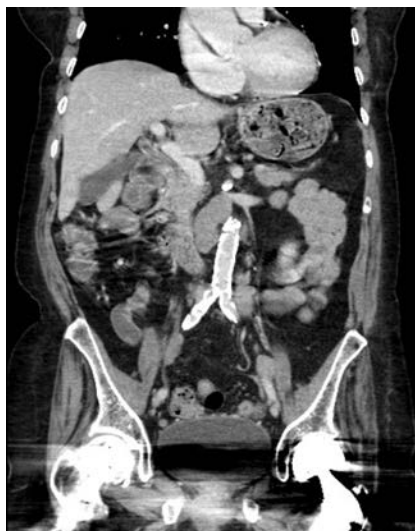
Coronal CT abdomen with metallic artefact obscuring bladder.
